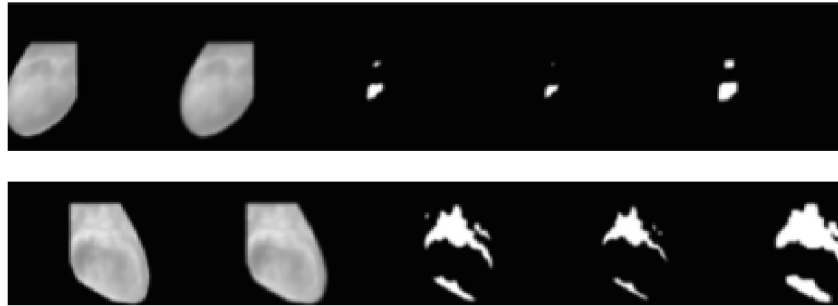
Extraction of the abnormal area. The first two images from the top are the MRI images of two different brains, and the remaining images are the thermal images of two different breasts. (Own work)
